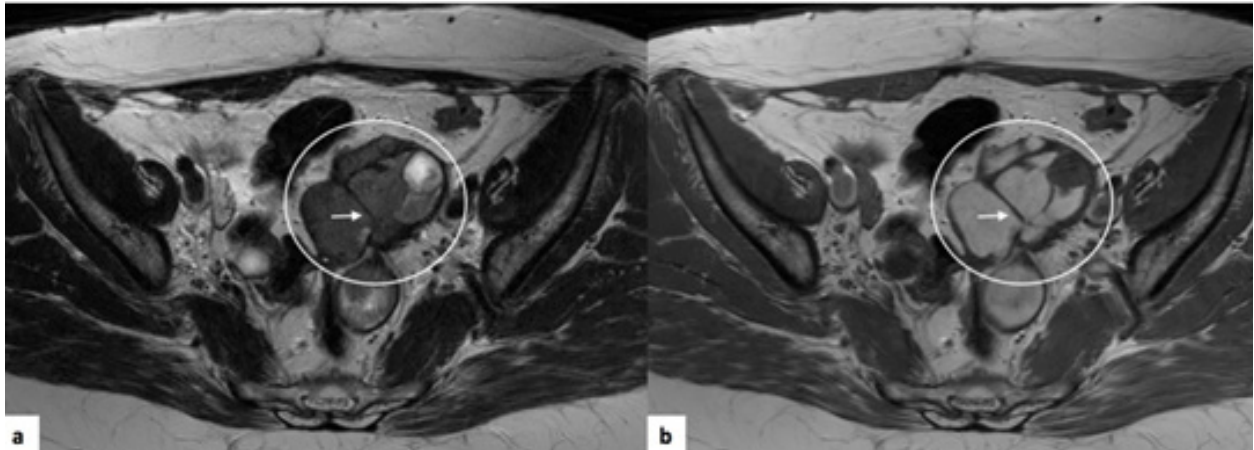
Haematosalpinx. Pelvic MRI of 49-year-old woman. (a) Axial T2-weighted image; (b) Axial T1-weighted image. It is possible to visualise a complex tumour in the left adnexal region (circle) with incomplete septa in its wall (arrows), which point to its tubal origin. On the T1-weighted image, it shows spontaneous high signal intensity, which corresponds to blood content (haematosalpinx).
